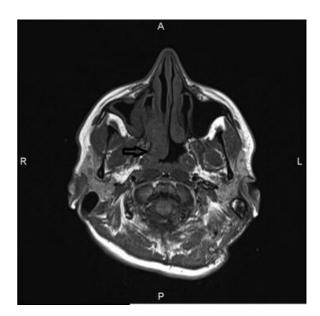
Preoperative maxillofacial magnetic resonance imaging (axial T1-weighted). Arrow shows the mass originating from the right inferior turbinate.
